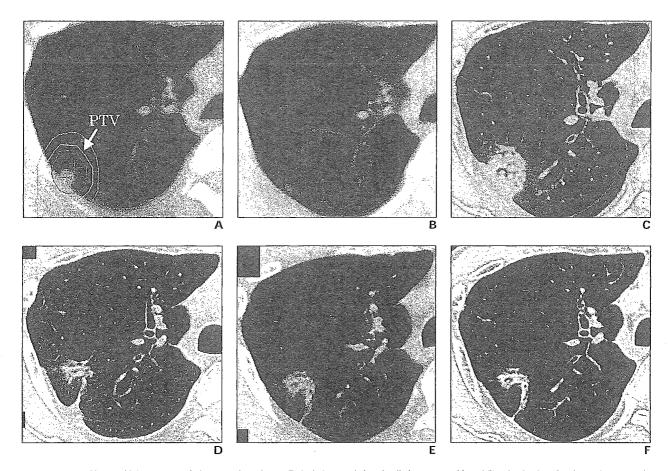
59-year-old man with lung metastasis from rectal carcinoma. Typical characteristics of radiation pneumonitis and fibrosis after hypofractionated stereotactic radiotherapy are seen on serial lung CT scans after irradiation.
